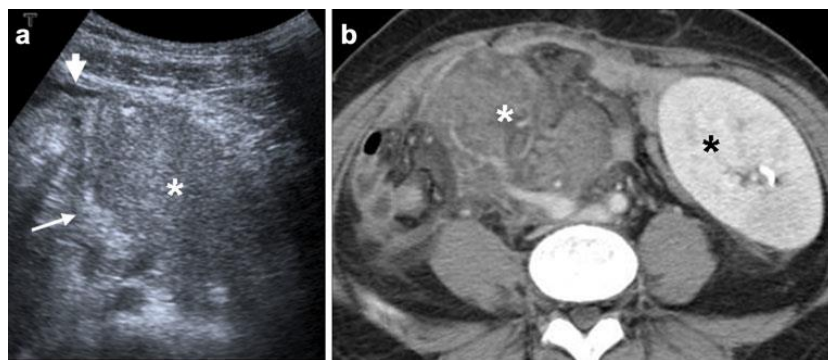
A 36-year-old woman after SPK transplantation presenting graft pancreatitis. a Ultrasound shows enlarged pancreatic graft (asterisk) with adjacent hyperechoic fatty tissue (thin arrow) and a small amount of free intraperitoneal fluid (large arrow). b Axial
